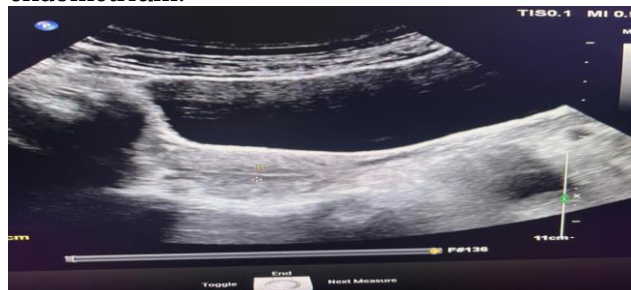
Transabdominal ultrasound revealed thin atrophic endometrium. The endometrial thickness (calipers) measures about 3.6 mm.
